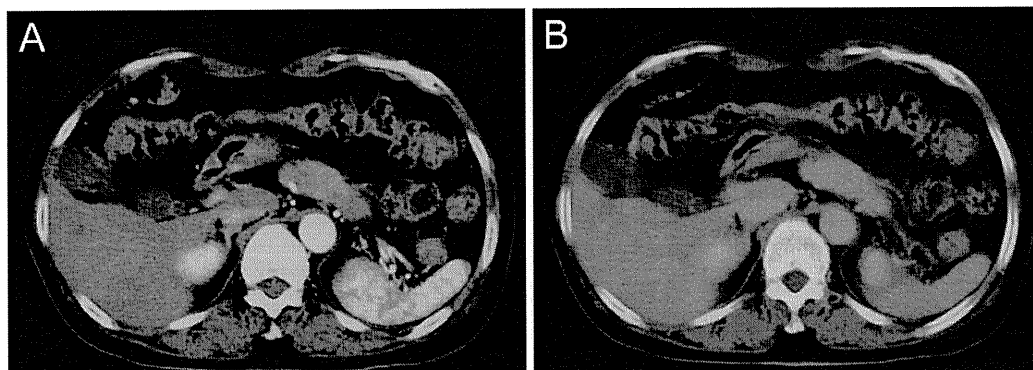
Contrast-enhanced computed tomography (CT) of the pancreas. Contrast-enhanced CT demonstrated moderate swelling in the body and tail of the pancreas with homogenous enhancement, but not capsular-like low density rim or swelling of peripancreatic nodes. (A) early phase (B) delayed phase.
